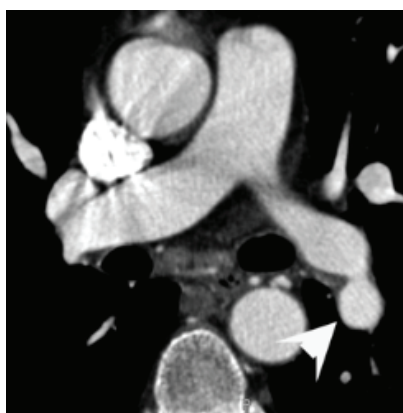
The computed tomography of the chest or computed tomography pulmonary angiogram and volume-rendered image reveal aneurysm of bilateral pulmonary arteries (white arrow and arrow head)
